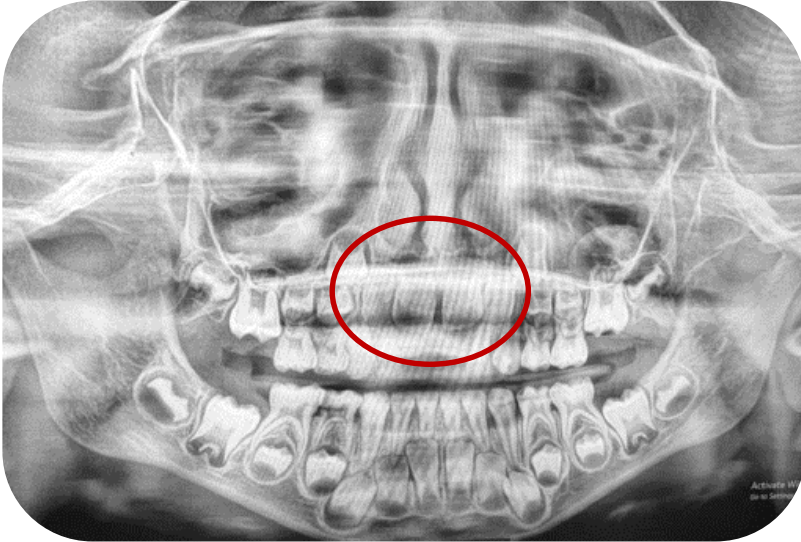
Panoramic radiograph two years later, showing normal development
